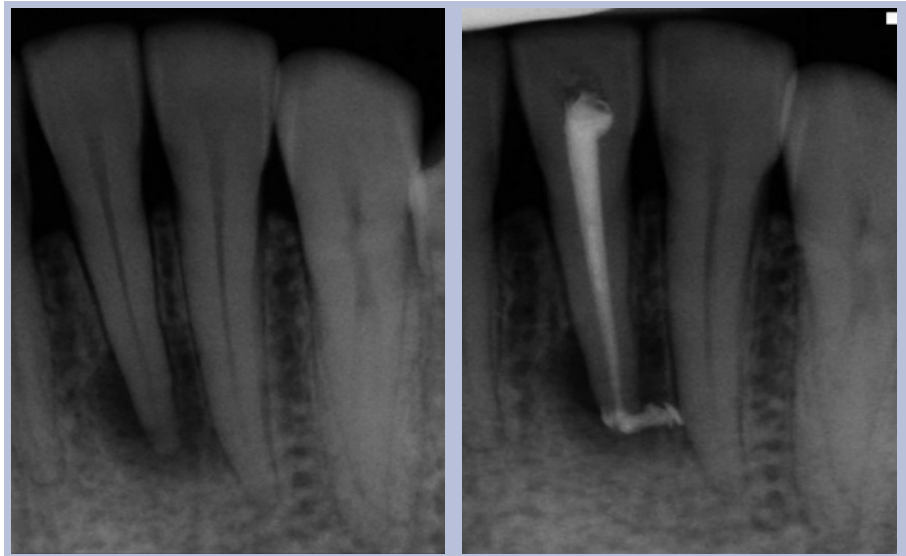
Periapical radiographs showing radiolucency on the lower left central incisor
